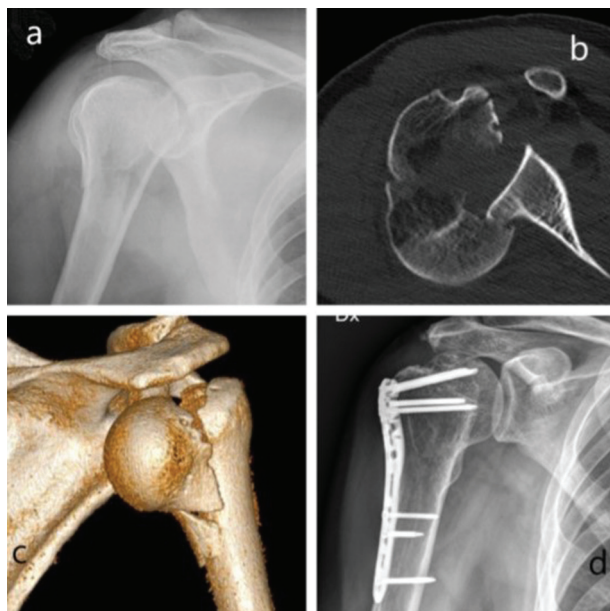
Imaging of patient T.D.: x-ray after trauma (a), axial ct of the fracture (b), 3d reconstruction of the fracture-dislocation (c), x-ray at follow-up (d)
